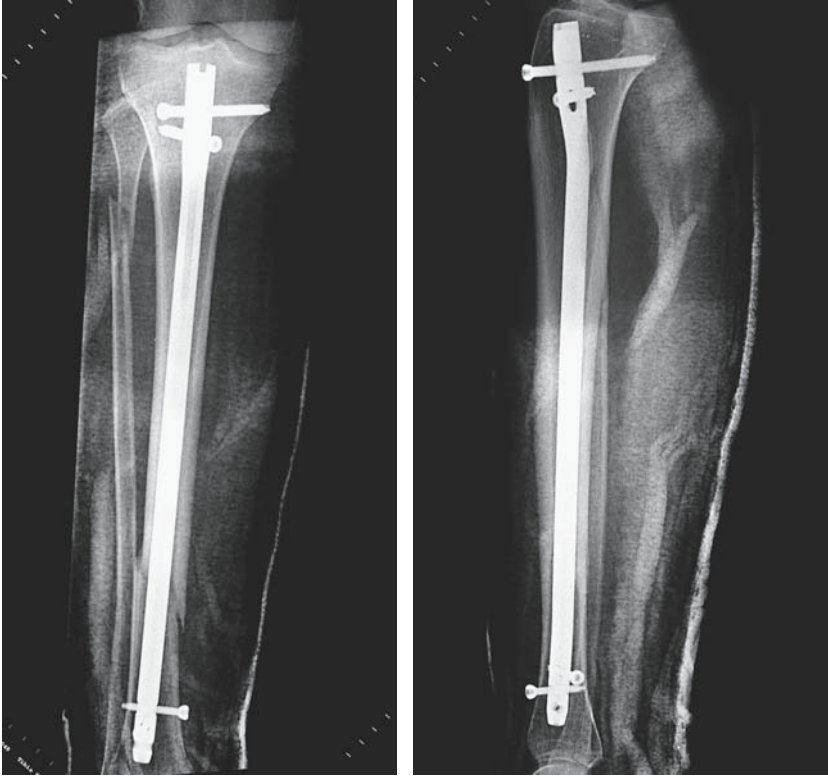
Immediate postoperative radiograph shows intramedullary nailing.
